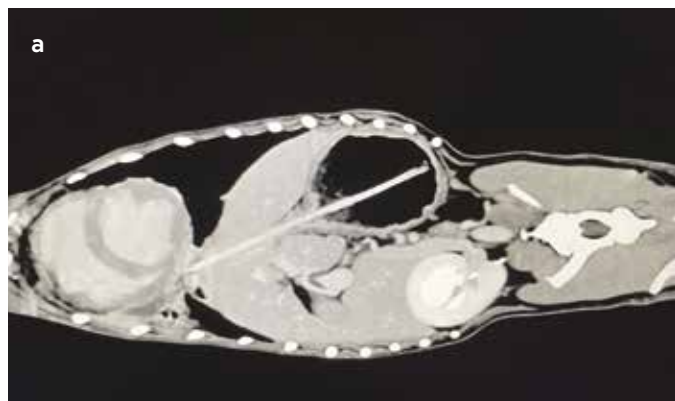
(a,b) Computed tomography scans showing a kebab skewer in the stomach. (c) Gastrotomy surgery for foreign body removal. (d) Closure of the stomach in two layers. (e) Foreign body after extraction.
